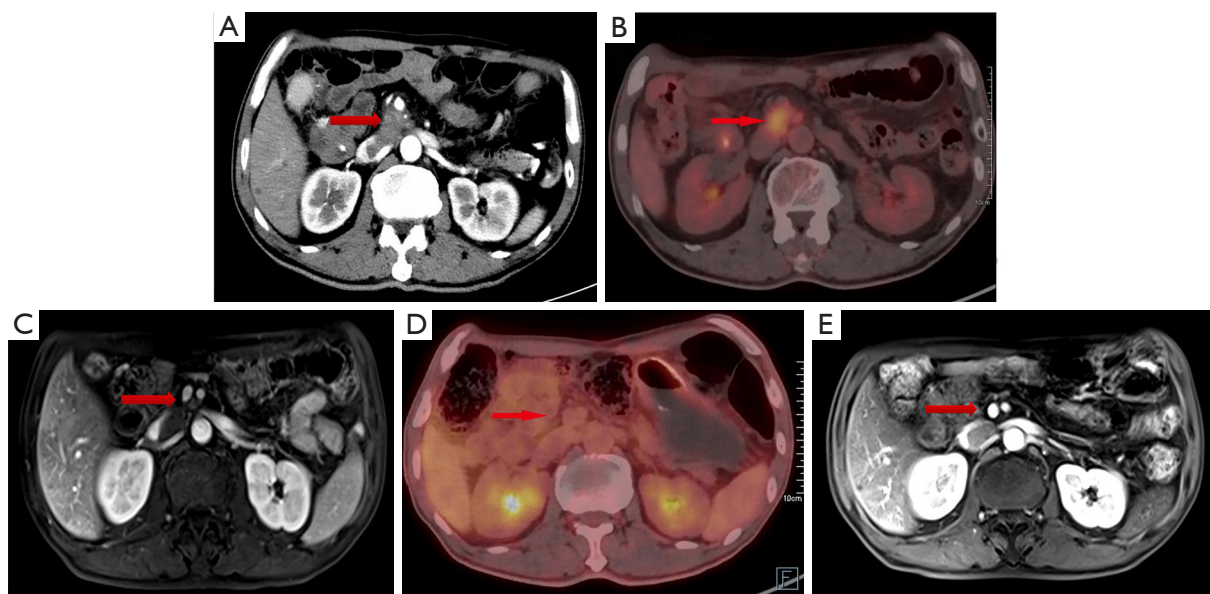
The comparison of upper abdominal imaging before and after chemotherapy with gemcitabine, oxaliplatin and nimotuzumab (Case 1). (A) The enhanced CT of upper abdomen showed that the lymph nodes behind superior mesenteric artery were enlarged and enhanced (red arrow). (B) The PET-CT showed that the enlarged lymph nodes with increased FDG metabolism (SUVmax =7.1) located at the same site as upper abdominal CT (red arrow). (C) After two cycles of chemotherapy, the enhanced MRI showed the metastatic lymph nodes were significantly reduced (red arrow). (D) After three cycles of chemotherapy, the metastatic nodules were not displayed by PET-CT (red arrow). (E) Enhanced MRI showed no recurrence at 13 months after chemotherapy (red arrow). CT, computed tomography; PET-CT, positron emission tomography-computed tomography; FDG, fluorodeoxyglucose; SUVmax, maximal standard uptake value; MRI, magnetic resonance imaging.
